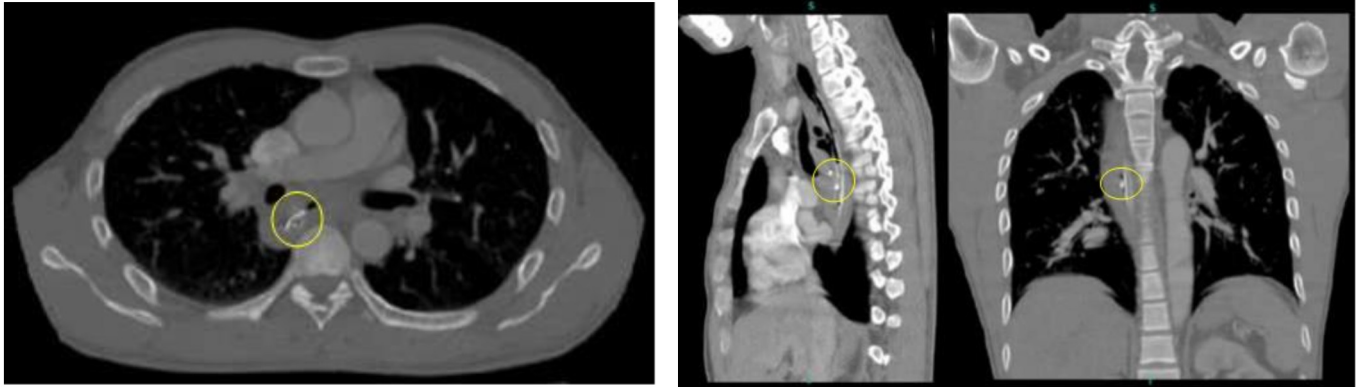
Axial, coronal and sagittal CT cuts showing linear hyperdensities (encircled) at levels T5-7
